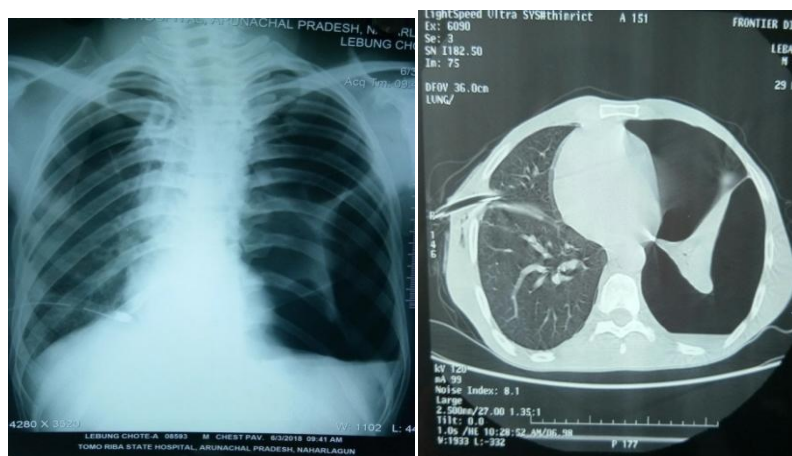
A.B Chest X ray PAV showing re expansion of of right side and CT Thorax showing massive left side pneumothrax with ICD tube on right side.
